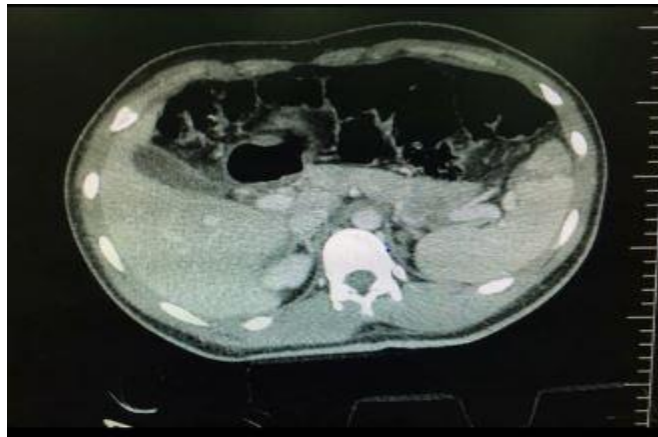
Spleen Abnormal CT scan
